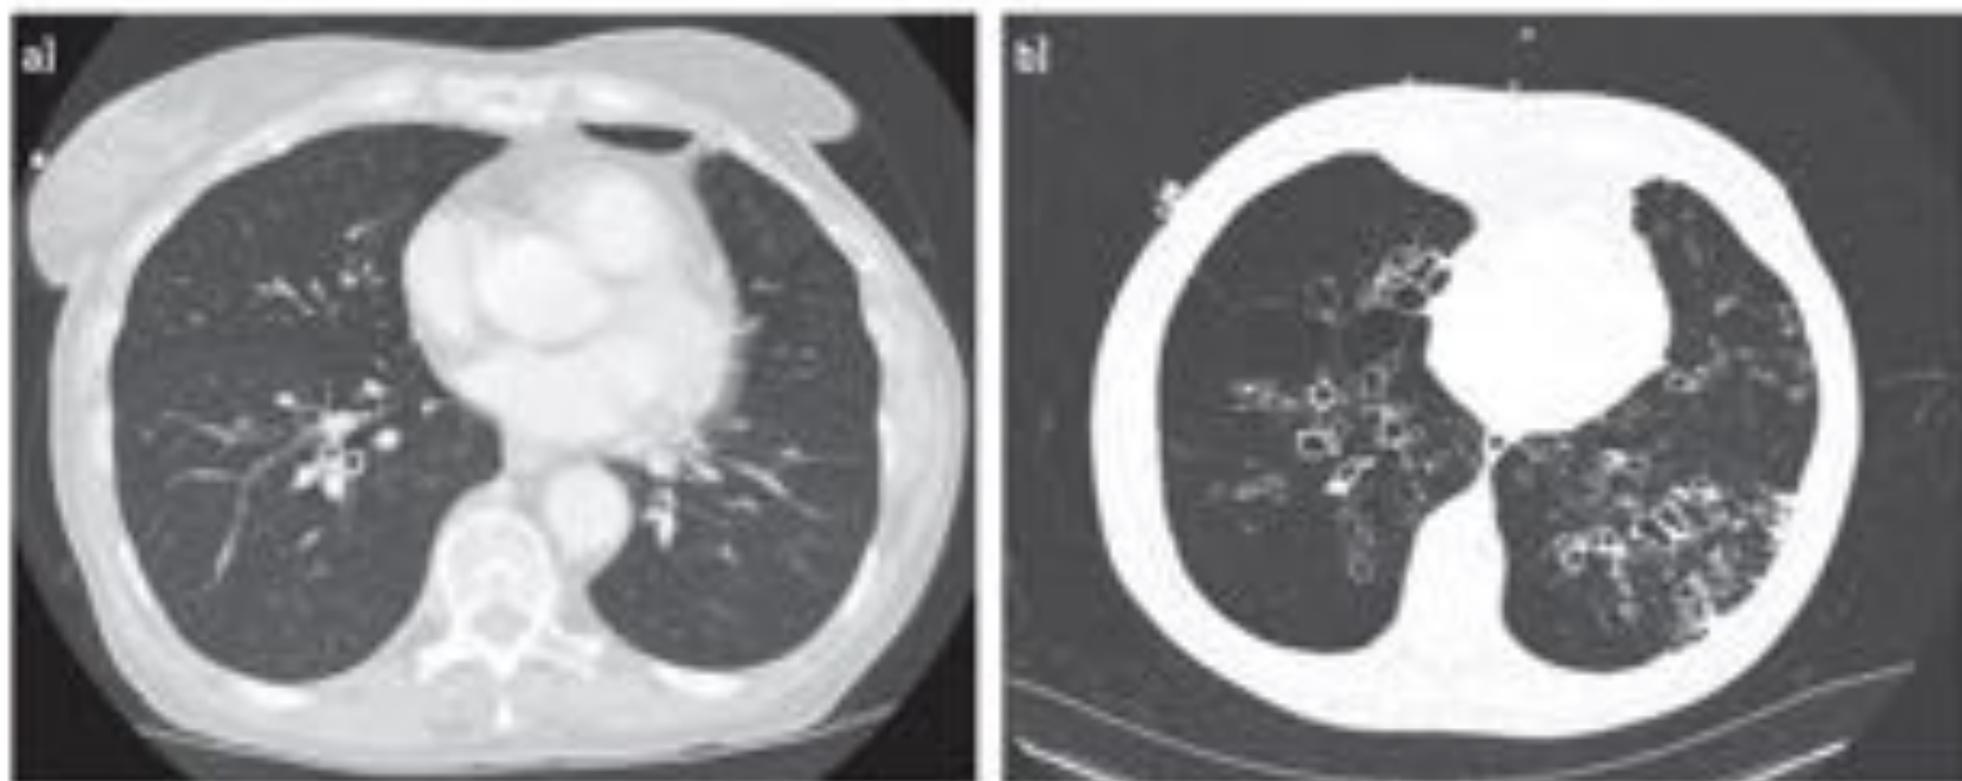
a) Typical airway wall changes in chronic obstructive pulmonary diagnosis are diffuse, and may be associated with co-existent emphysema on computed tomography. b) Airway wall changes in primary bronchiectasis may be localised or diffuse, and may be more severe resulting in cystic and/or varicose appearances.
